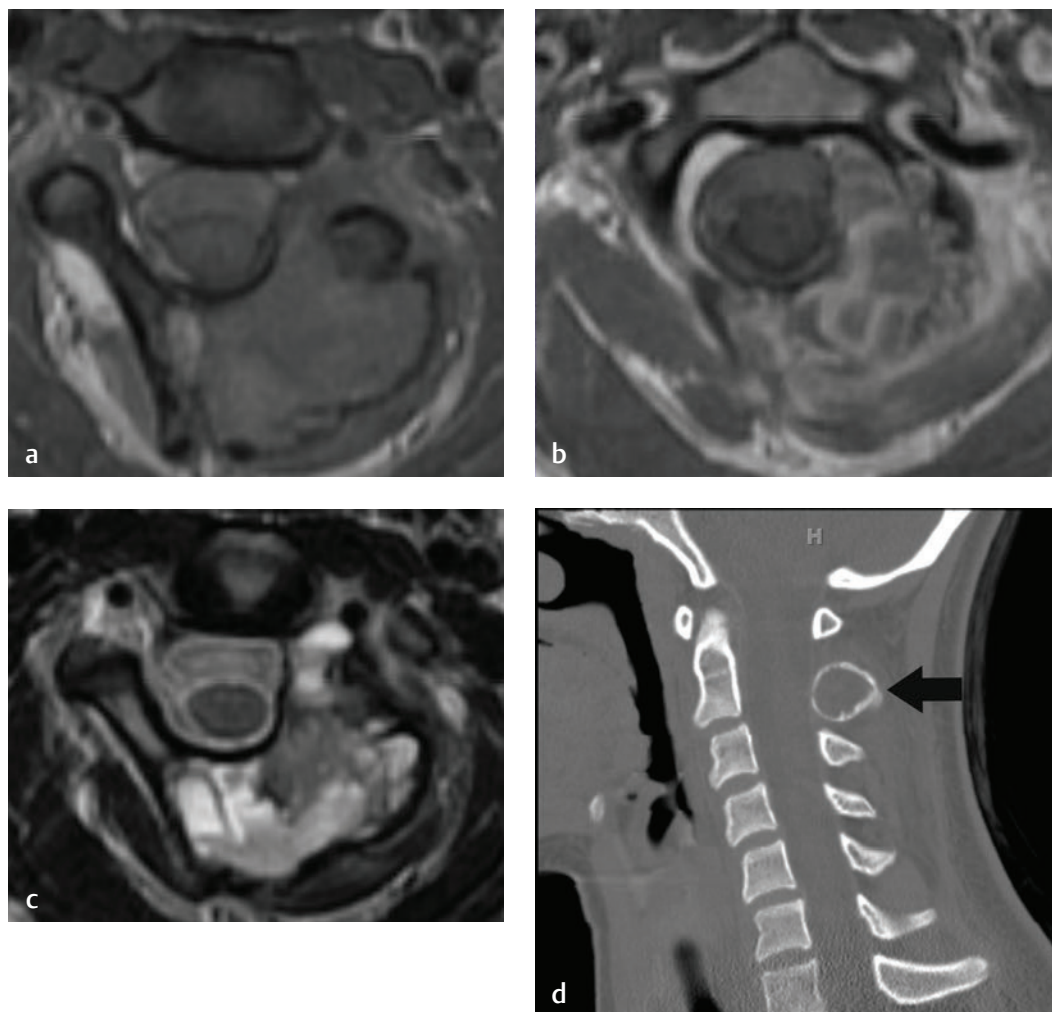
Left-side cervical osteoblastoma. Axial (a) precontrast and (b) postcontrast T1-weighted images show a lesion similar to (but larger than) the osteoid osteoma shown in Fig. 8.5. The lesion shows heterogeneous contrast enhancement with infiltration into the epidural space. (c) An axial T2-weighted image also shows the lesion. (d) A sagittal CT reconstruction highlights the osseous destruction and expansion associated with the osteoblastoma in the spinous process (*arrow*).
